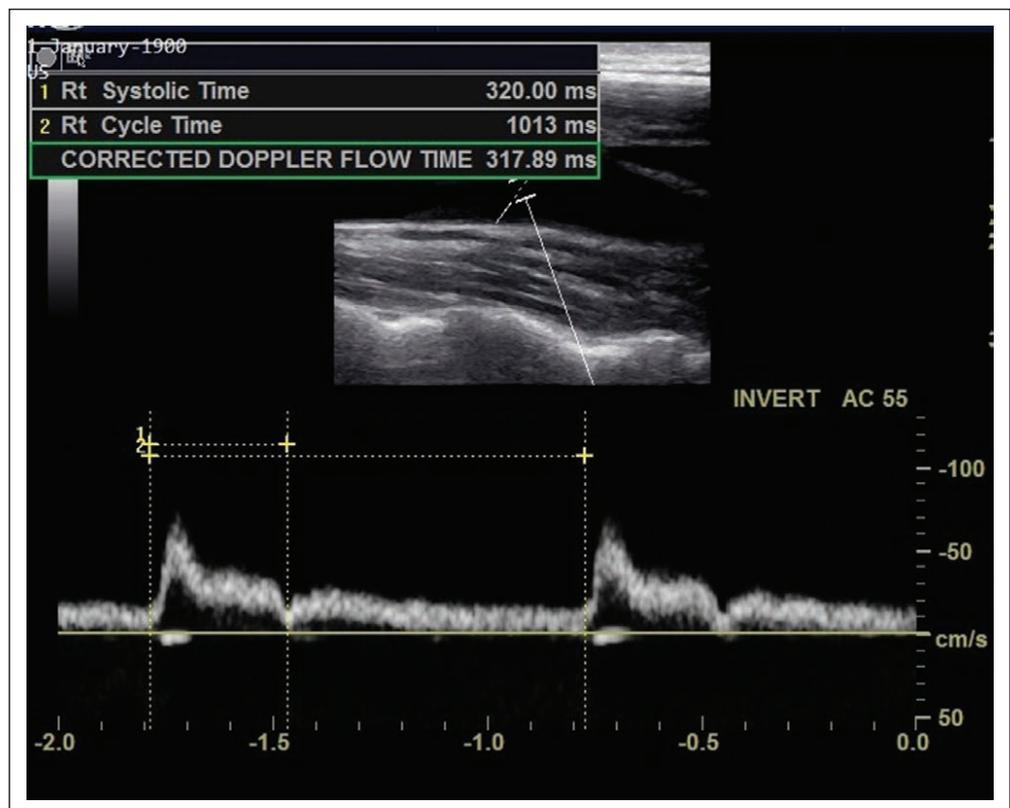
Carotid Doppler waveform with markings: 1) flow time (FT) and 2) cycle time. Carotid corrected FT is calculated as $FT + 1.29 \times (\text{heart rate} - 60)$. AC = angle correction, Rt = right side.
